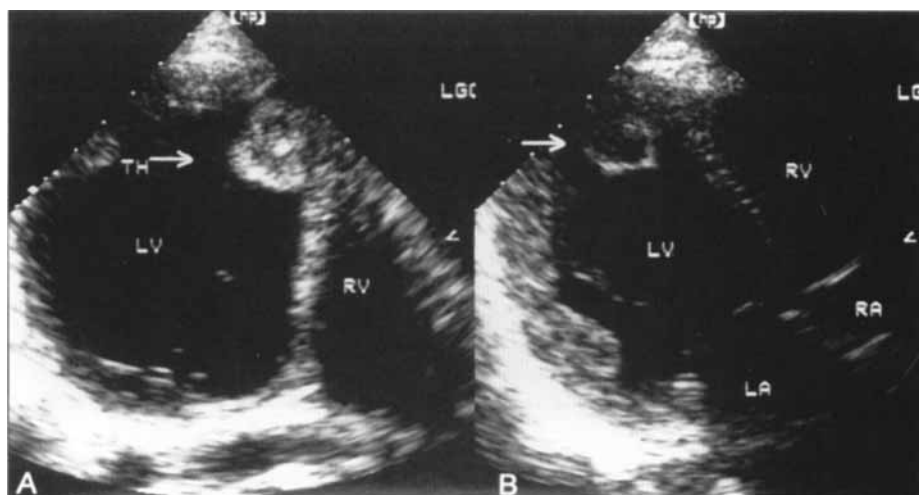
Transthoracic echocardiography: (A) Apical four-chamber view shows a large, round echogenic mass attached at the apical septum, suggestive of thrombus (arrow). (B) A modified apical four-chamber view reveals a similar finding. LA = left atrium, LV = left ventricle, RA = right atrium, RV = right ventricle.
